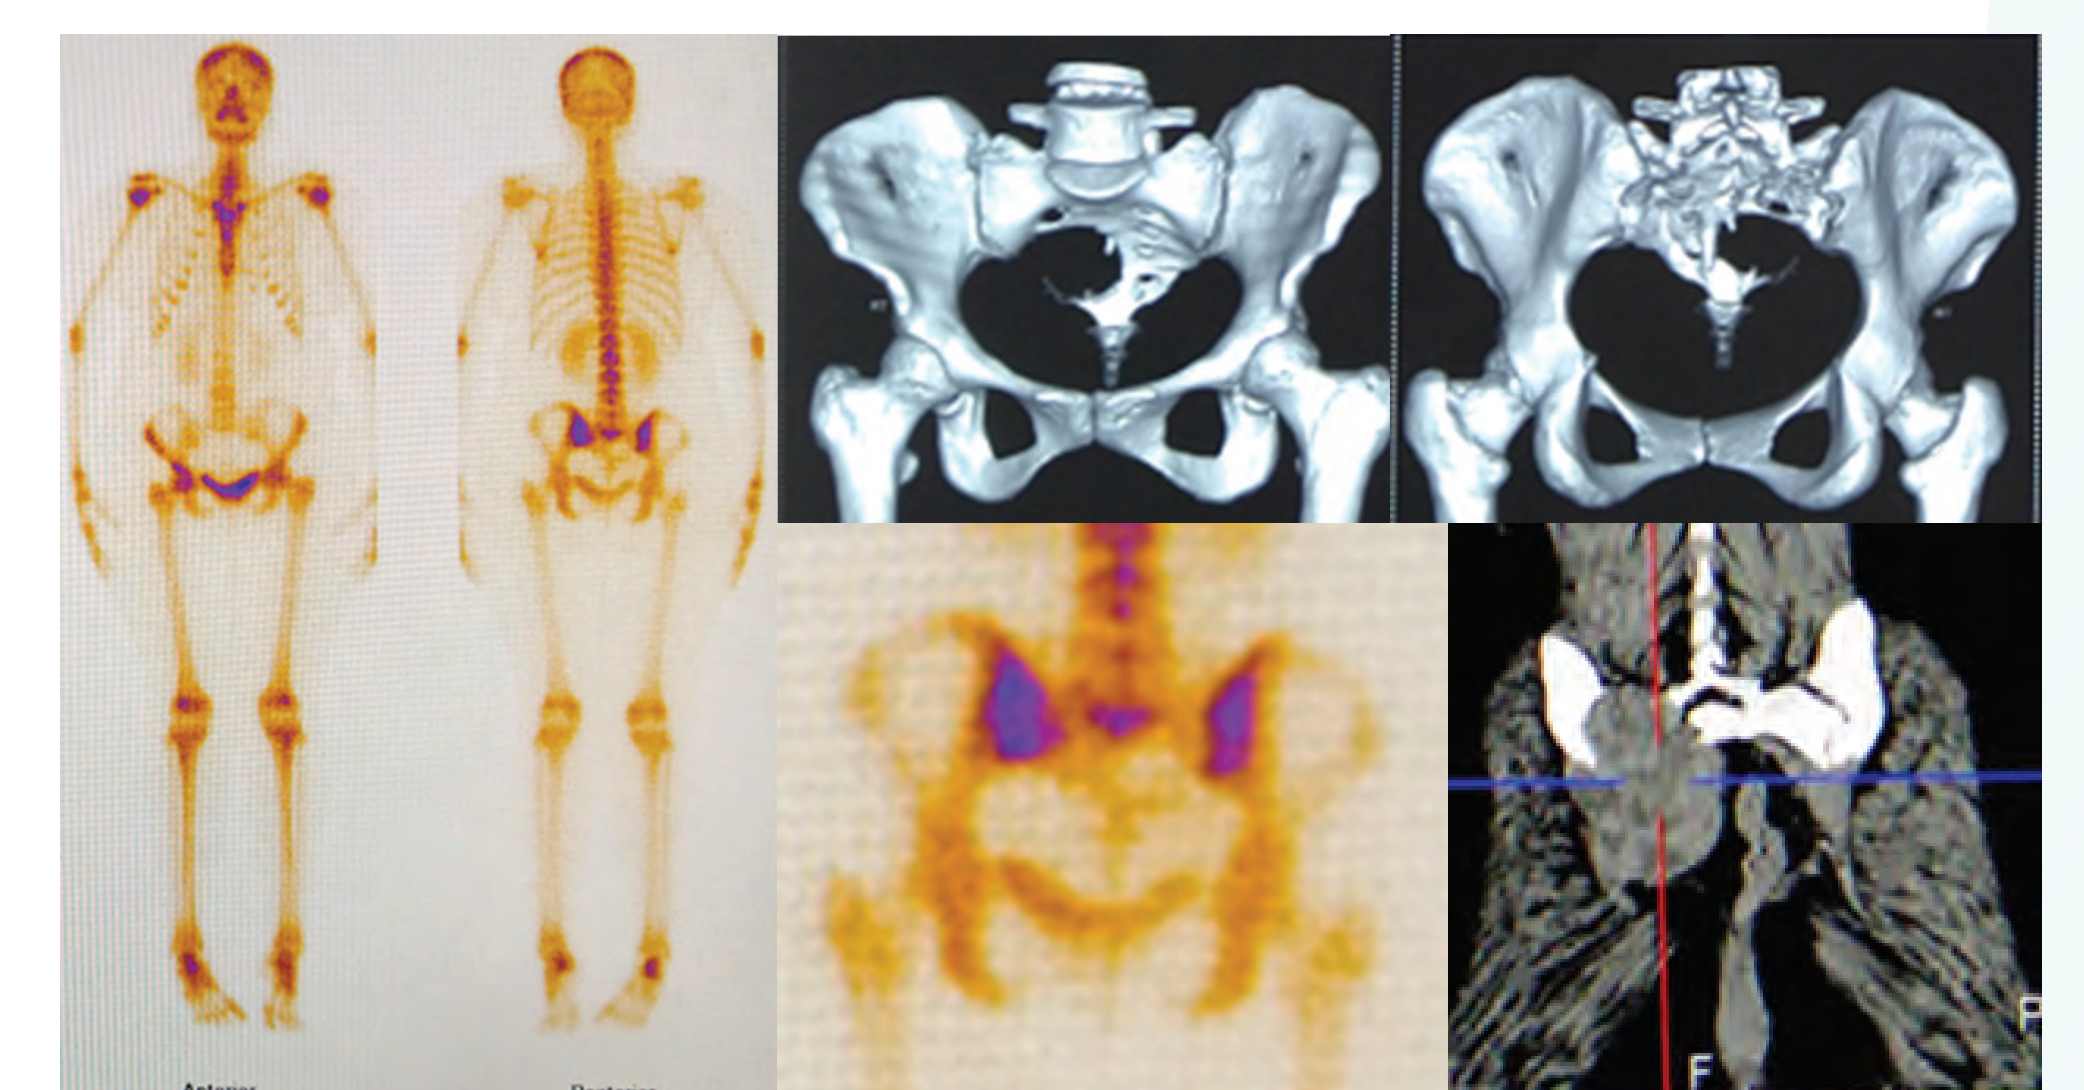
^{99m}Tc-MDP whole body bone scan and spot image of pelvis showing photopenic area at right sacral ala; expansile osteolytic lesion with soft tissue mass in corresponding CT images.
